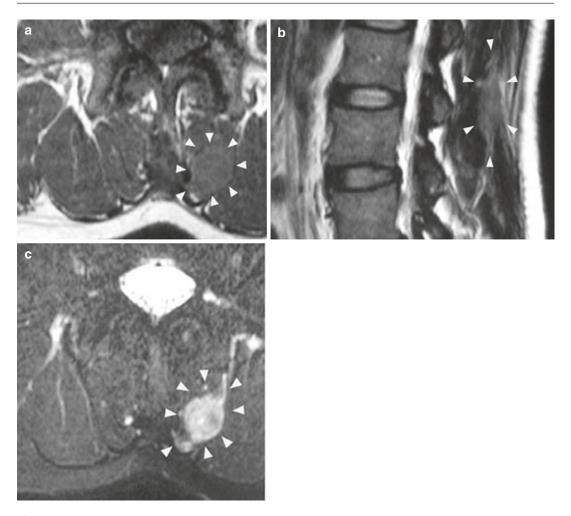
(a-c) Fig. 13.37 a-c. Low-grade myofibroblastic sarcoma. MRI of the lower spine in a 46-year-old woman. T1-weighed images revealed an iso- to highintensity mass in the multifidus muscle (a, *arrowheads*).
